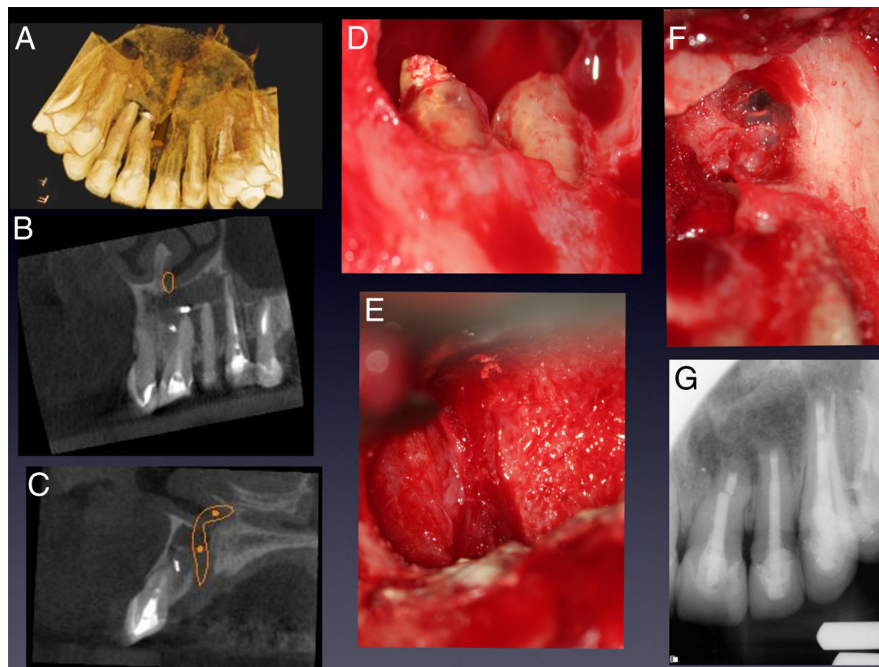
Case 4 continued: (A) A palatal view CBVT reconstruction showing the exit of the nasopalatine bundle from the incisive canal. (B) The sagittal view showing periapical radiolucency involving teeth #9, 10, and 11. (C) The coronal view of the exit of the nasopalatine bundle from the incisive canal. (D) A periapical defect after degranulation showing the apices of teeth #9 and 10 before resection. (E) A clinical picture of the nasopalatine duct intact after degranulation. (F) The lateral wall of the maxillary sinus distal to tooth #11. (G) An immediate postoperative radiograph after grafting the through-and-through defect with Puros allograft (Zimmer Dental, Warsaw, IN) material and, CopiOs membrane.
